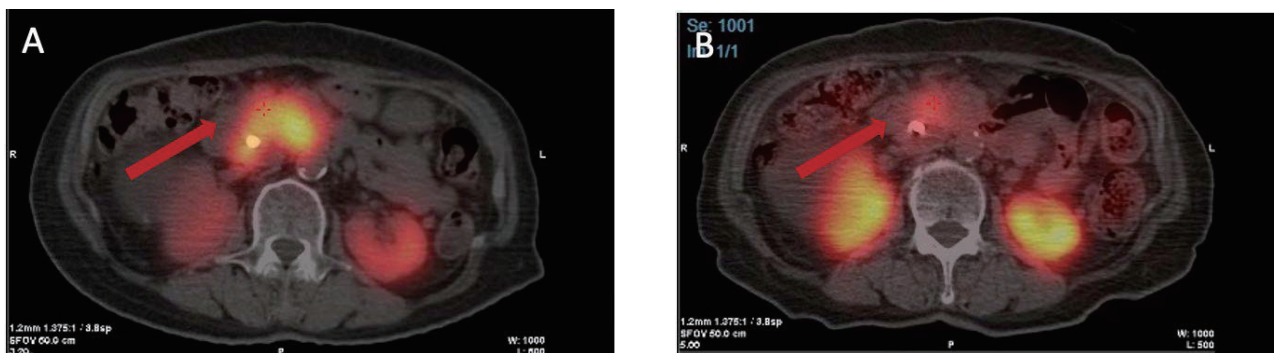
Post-treatment planar SPECT images acquired 24 hours after PRRT demonstrate a significant reduction in the primary tumor burden, with complete resolution of the main lesion observed when comparing images after the first and fourth treatments.(A) Planar SPECT image 24 hours after the first treatment showing radiotracer uptake in the pancreatic head tumor, mesenteric root, and mild heterogeneous uptake in the liver (arrow).(B) Planar SPECT image 24 hours after the second treatment showing a marked reduction in radiotracer activity in the pancreatic head tumor. (C) Planar SPECT image 24 hours after the third treatment.(D) Planar SPECT image 24 hours after the fourth treatment showing significantly reduced radiotracer uptake in the primary lesion.
